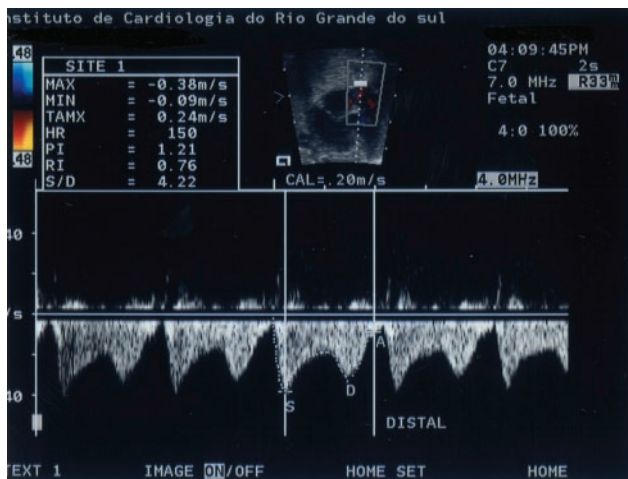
Doppler tracing of a typical distal pulmonary vein flow. Velocities were electronically calculated after manual tracing of waveforms. Presystolic velocity is 0.09 m/s, and calculated pulsatility index is 1.21.
